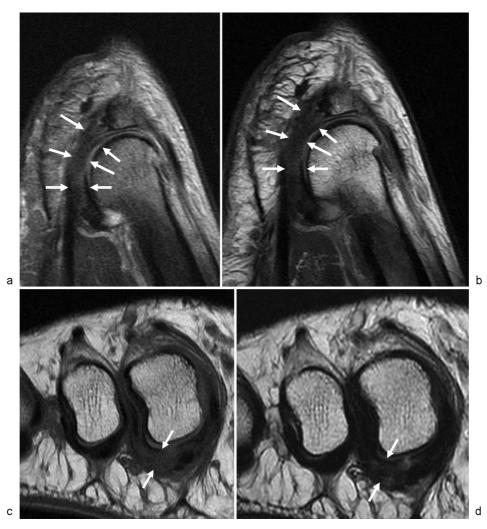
A 46-year-old man presents with a painful second MTP joint. (a) Sagittal fat-suppressed proton-density (PD), (b) sagittal PD MR images, (c) short-axis T1, and (d) short-axis T2 images through the second MTP joint demonstrate severe degeneration of the lateral plantar plate that manifest as signal hyperintensity on PD and fat-suppressed PD sequences (arrows), more marked on T1 sequencing (arrows) and less conspicuous on T2 sequencing (arrows), with elongation of the plantar plate but no discrete tear.
